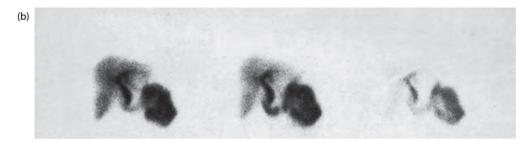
Biliary scintigraphy with EHIDA: (a) normal cholescintigram – both the gallbladder and the bile duct are imaged; (b) acute cholecystitis – a normal bile duct with prompt excretion into the duodenum is observed but the gallbladder is not outlined.
